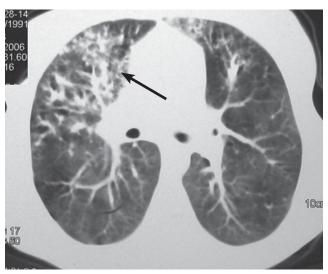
Pulmonary CT – «matte glass syndrome», fibrosis zones, varicose and sacciformes bronchiectasis, signs of bronchiolitis (in cortical areas, Y-type). 15-year-old child with CF, S. aureus chronic infection, CFTR genotype delF508/delF508
